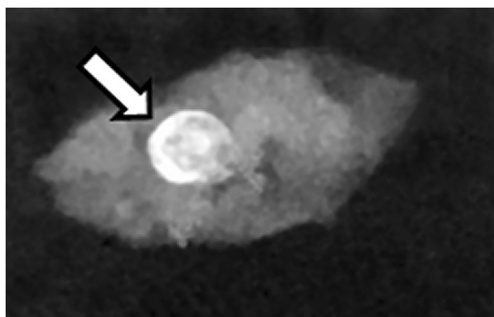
Radiograph of the resected tissue performed during the surgical intervention shows the presence of a round calcified lesion within the resected tissue (arrow)
